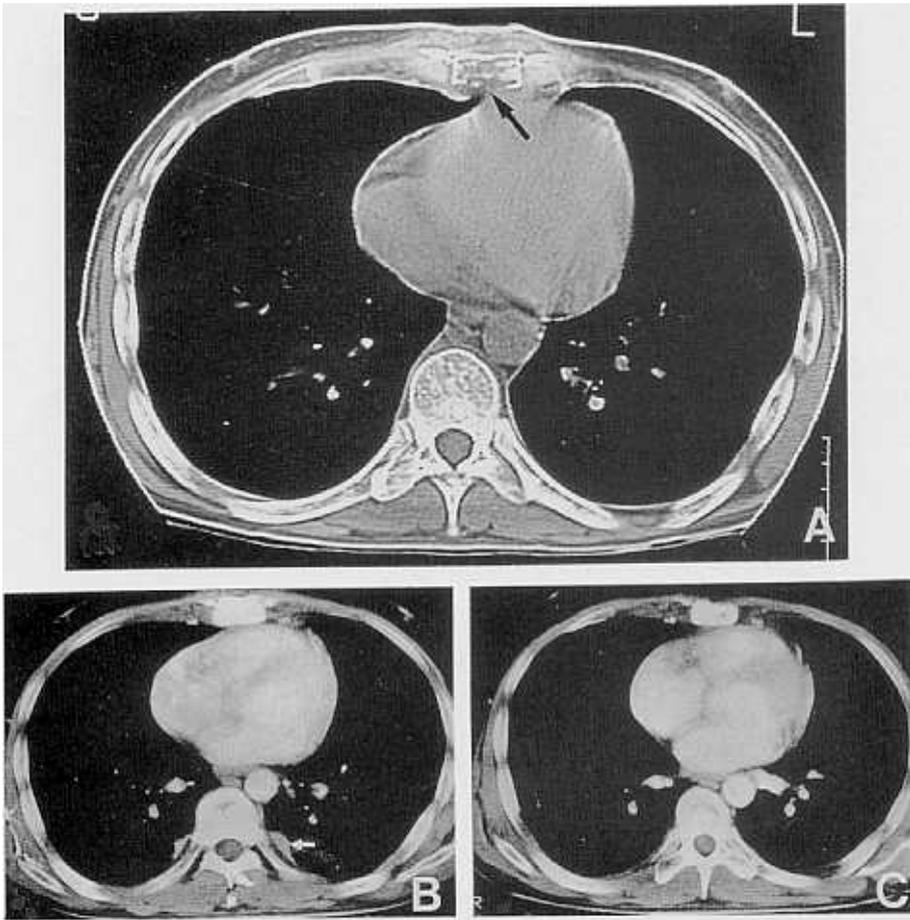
Chest CT scan showing multifocal cortical bony erosion at the low sternal body combined with surrounding soft-tissue mass (A). Focal pleural thickening was noted at the posterior costal pleura after radiotherapy (B). Previously-destructed sternal lesion and focal pleural thickening were improved after 3rd cycle of chemotherapy (C).
